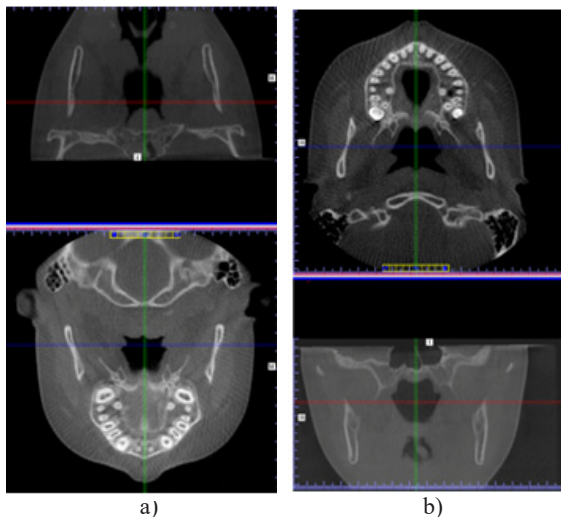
Axial and frontal sections of cone-beam computed tomography of the respiratory tract of patient C. before (a) and after treatment (b)
